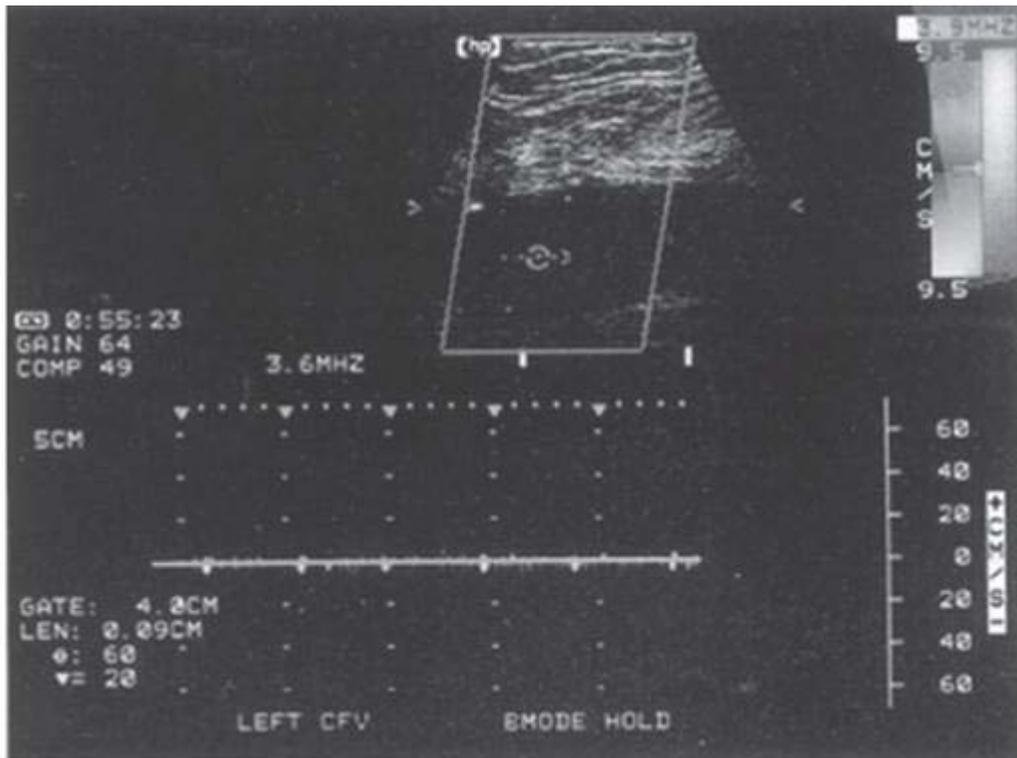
Duplex ultrasound of a femoral vein containing thrombus demonstrating no flow within the femoral vein
